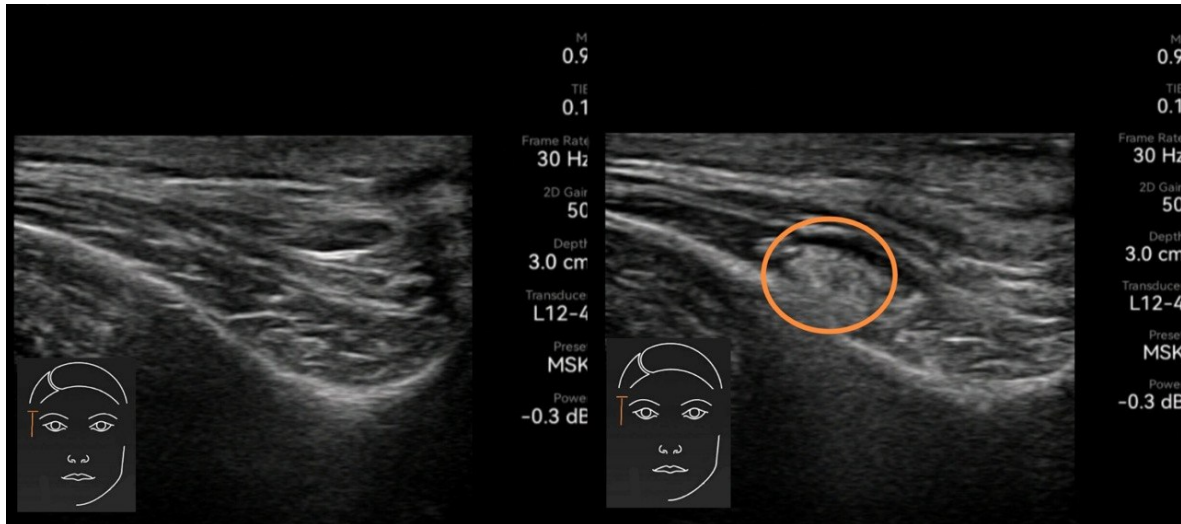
Ultrasonic image of the Agarose filler over the bone, of the first patient.*
